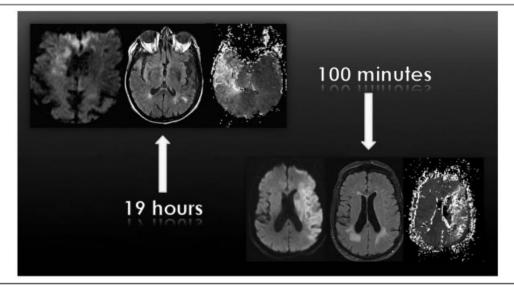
Detailed imaging of acute middle cerebral artery stroke (left to right: diffusion-weighted imaging, fluid-attenuated inversion recovery, time-to-peak perfusion magnetic resonance imaging) shows that one cannot tell time from images because marginal tissue damage may be present at 19 hours (left) compared with more extensive injury at 100 minutes (right).
